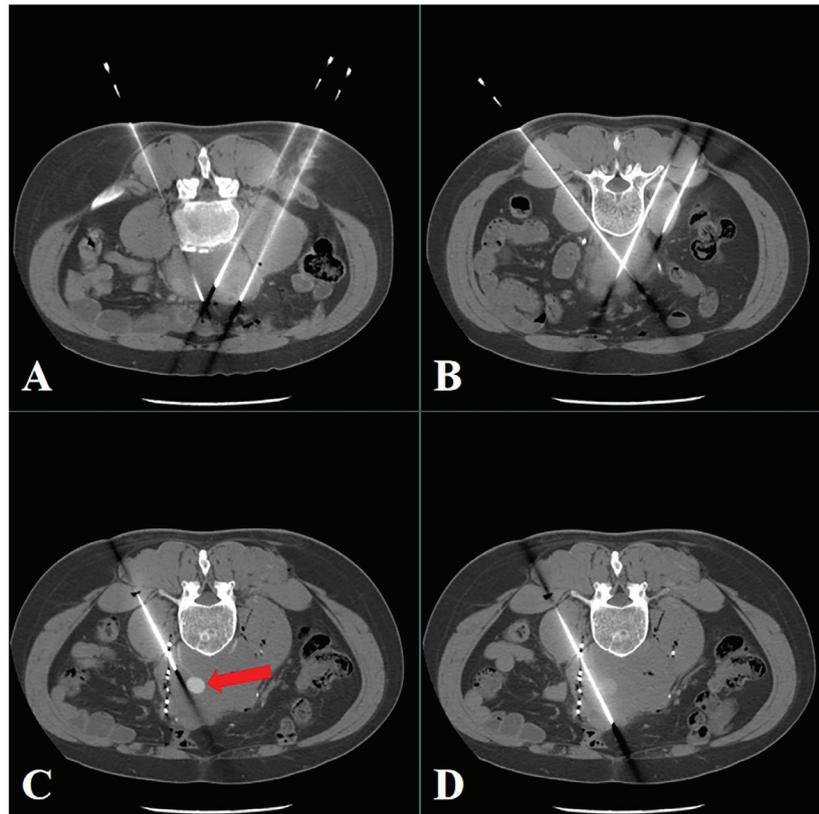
During the procedure, GE Revolution HD computed tomography was used for guidance. A 5-mm thickness was selected for spiral scanning, and the (A) lumbar and back approach was used for the puncture path. (B) The puncture needle was inserted step-by-step to ensure that the surrounding organs were not damaged. (C) When the boundary between the tumor and the abdominal aorta (red arrow) appeared unclear during the operation, a real-time enhanced scan was used to guide the puncture, thus avoiding the abdominal aorta. (D) The puncture needle successfully avoided the abdominal aorta and reached the distal end of the tumor.
